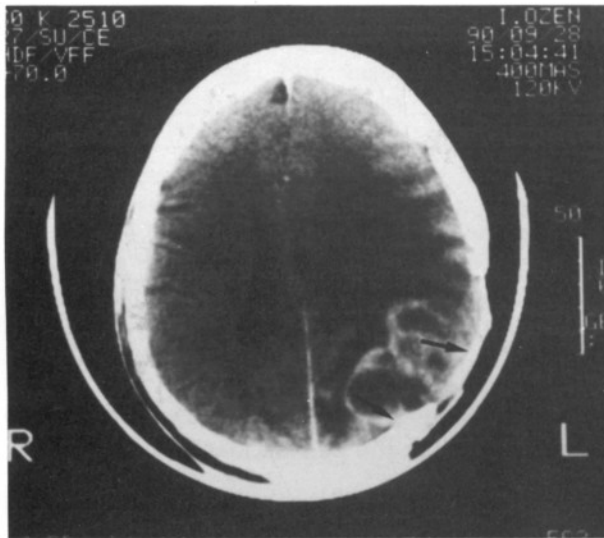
CT scan with contrast shows extension of recurrent glial tumour with ring contrast enhancement in the left parieto-occipital region. Tumoral lesion infiltrated dura mater and cranium (arrows).
